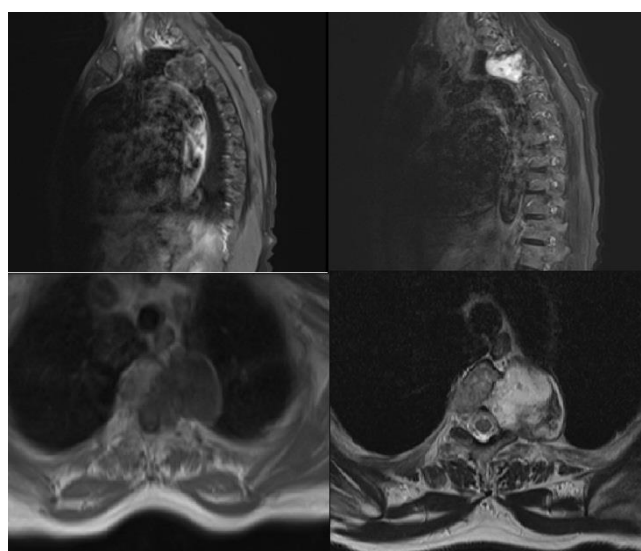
Magnetic resonance images of the patient (at T4 level)
